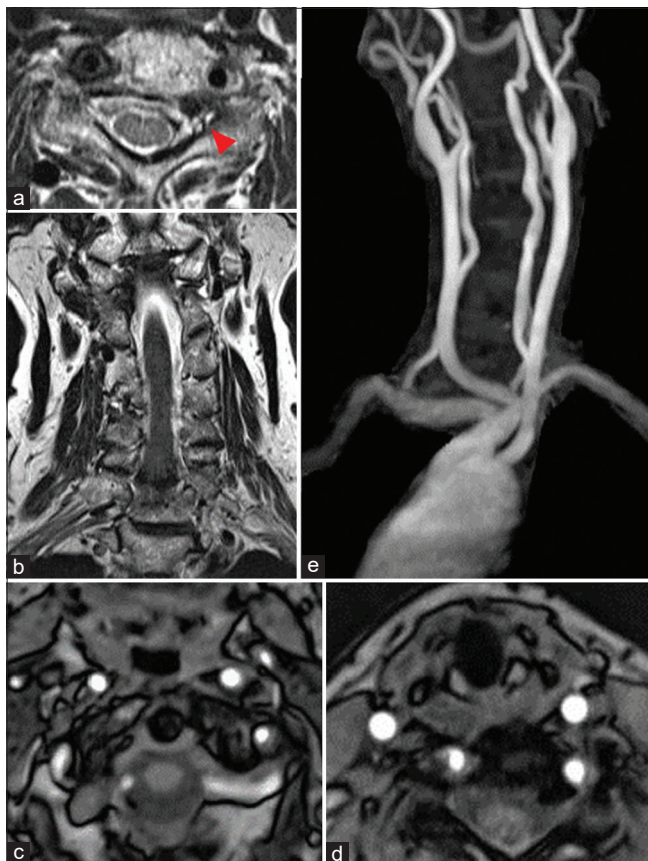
Postoperative MR image. The T2-weighted axial (a) and coronal (b) images 4 years after embolization showed reduction of flow voids of the left anterior internal vertebral venous plexus (arrowhead) at C4, and improvement of compression of nerve roots and spinal cord. The MIP images demonstrated no recurrence of the fistula at C2 (c) and C5 (d). The neck MR angiography obtained 4 years later demonstrated that the fistula was completely occluded (e).
